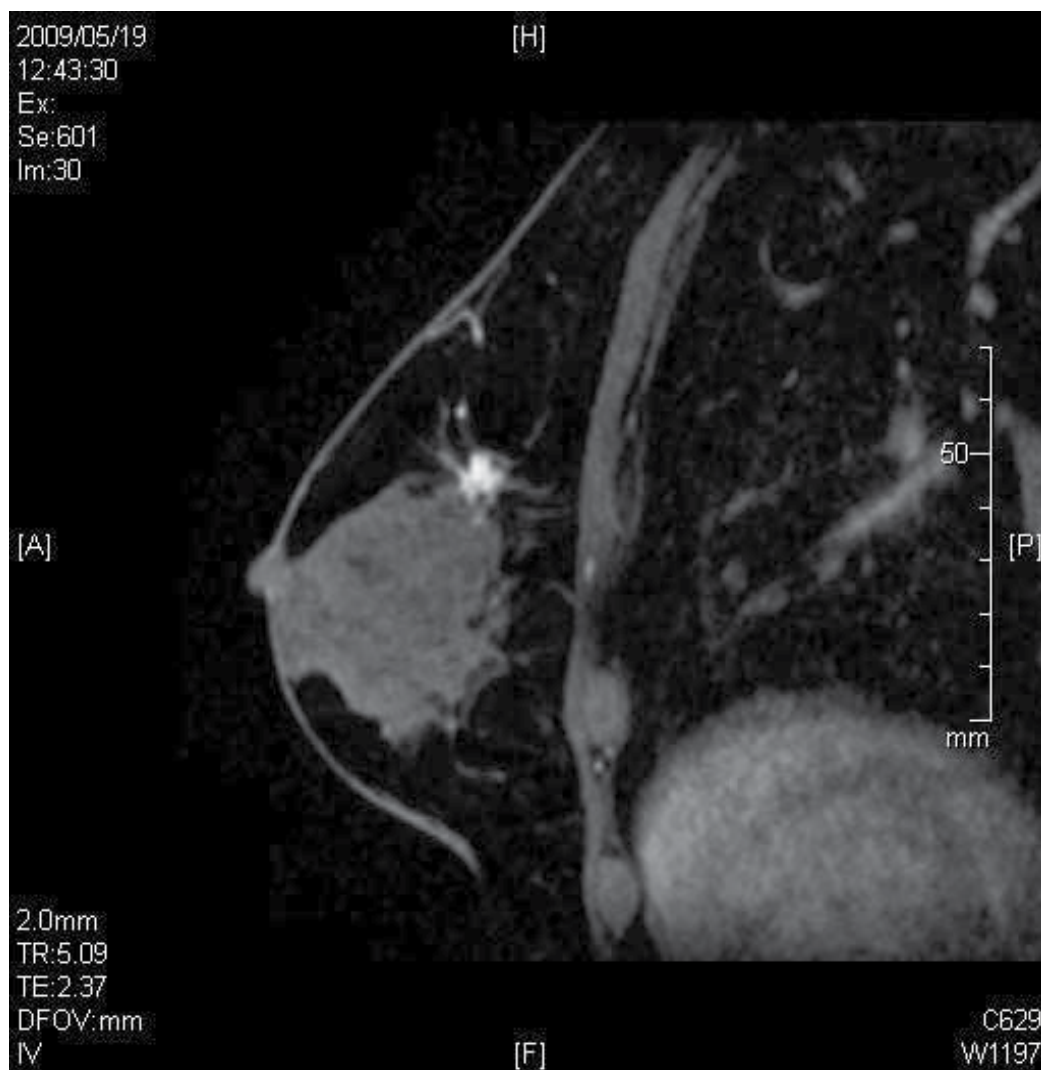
A first representative case of DCIS, MRI.
